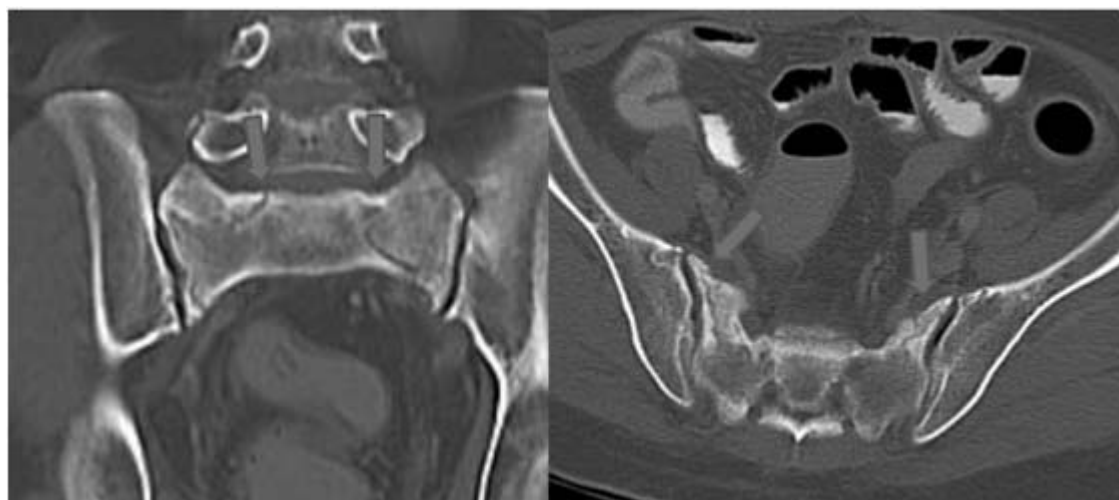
Coronal and Axial CT scan showing fracture line along bilateral sacral alae with interruption of the anterior cortex of the sacrum. They extend posteriorly, parallel to the sacroiliac joints.
